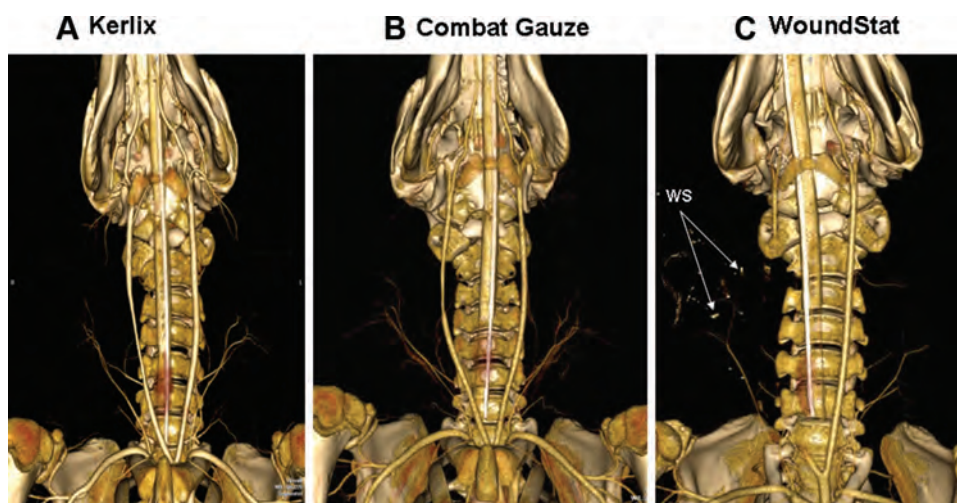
CT images of blood flow through the carotid arteries 2 hours after reflow. Note the narrow blood flow through the arteries treated with KX (A) or CG (B) and the lack of blood flow in a long segment of the right carotid artery treated with WS (C). Arrows show the WS residue in the wound.
